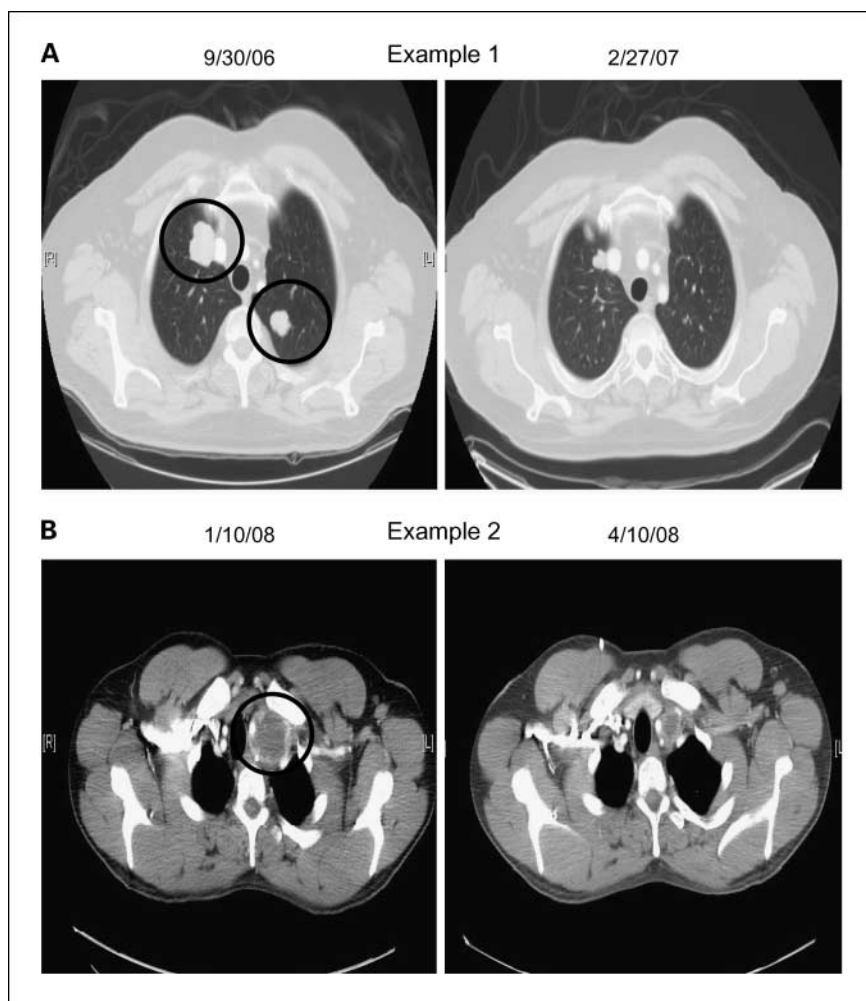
Radiographic examples of GCT response. Two cisplatin-refractory GCT patients showed areas of disease pretreatment (circled in black), which decreased by 65% (Example 1) and 43% (Example 2) posttreatment.
